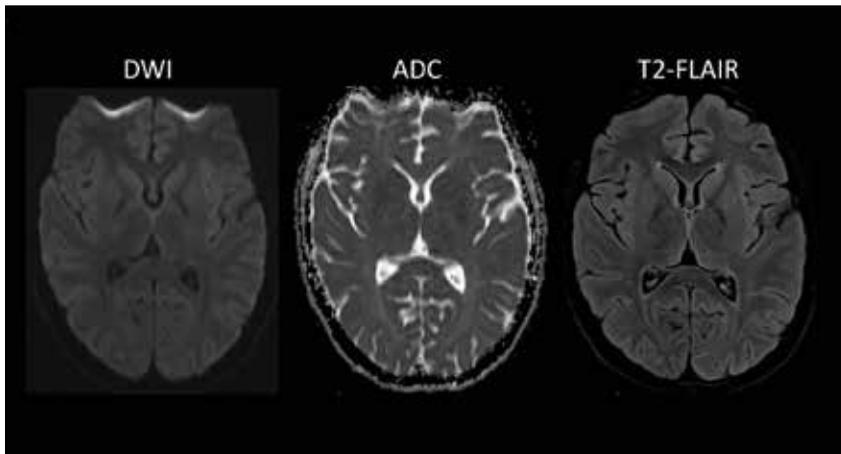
Diffusion weighted images (DWI), ADC maps and axial T2-FLAIR weighted images show complete resolution of the splenial lesion at follow-up MRI.
